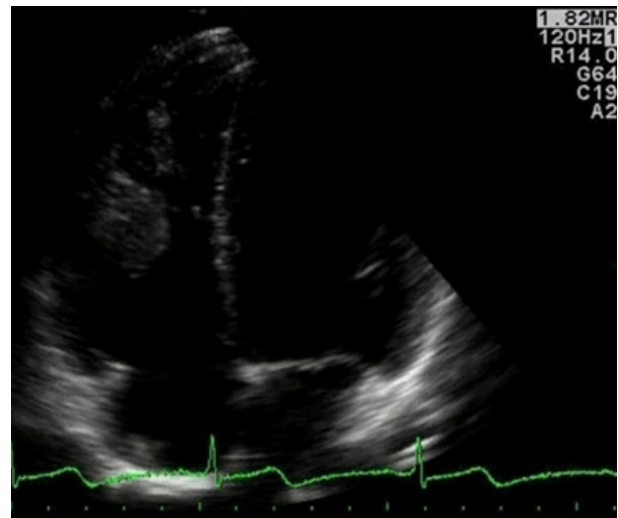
Pre-chemotherapy transthoracic echocardiography: showed right ventricular mass. The mass is attached to the free wall of the right ventricle.
